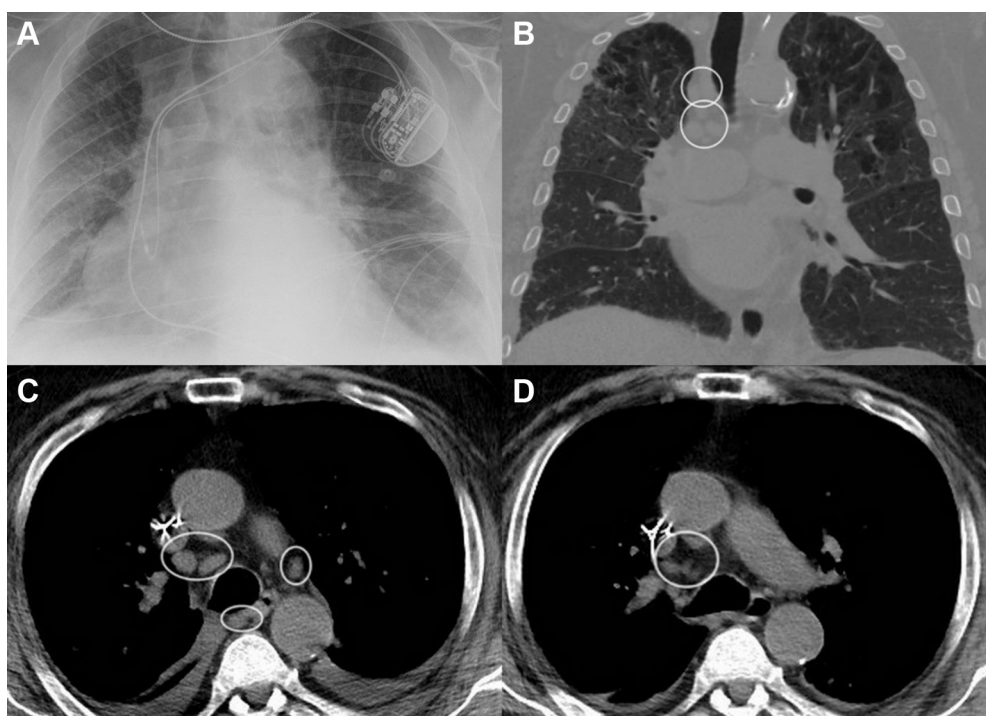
A, Chest radiograph of a patient with acute exacerbation of heart failure. Coronal (B) and axial (C, D) CT scans showing congestive lymphadenopathy in a case of acute exacerbation of heart failure (circles in B and C), with resolution after treatment with diuretics (circle in D). Note pacemaker (A).
